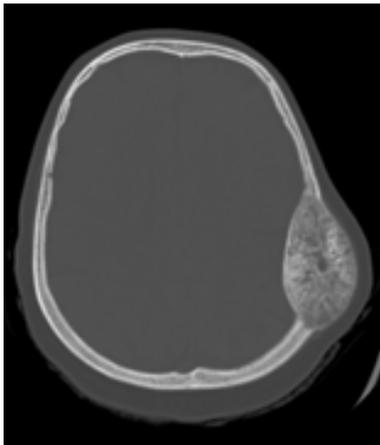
CT Shows Expansile Lesion with Lytic Areas in Calvarium
